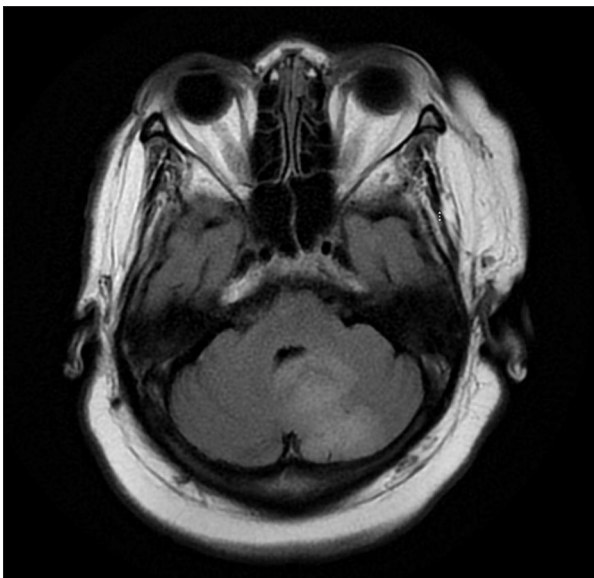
Magnetic resonance imaging of the brain (T2 flair image) showing abnormal signal in the left posterior inferior medial cerebellum, which showed bright signal intensity on T2 and flair.
